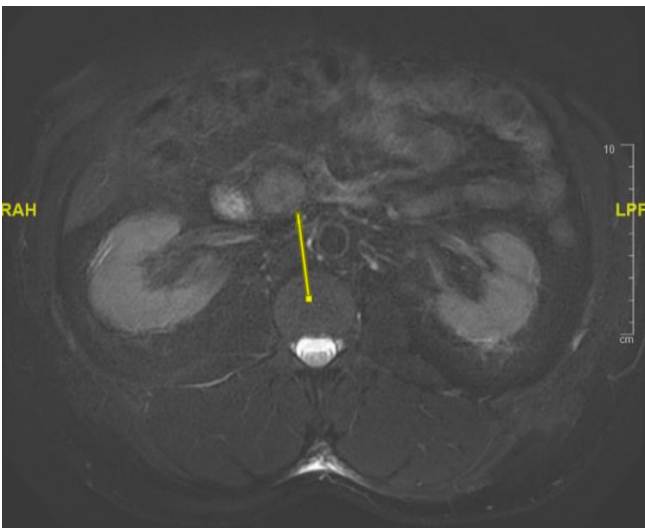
MRI abdomen at presentation.
